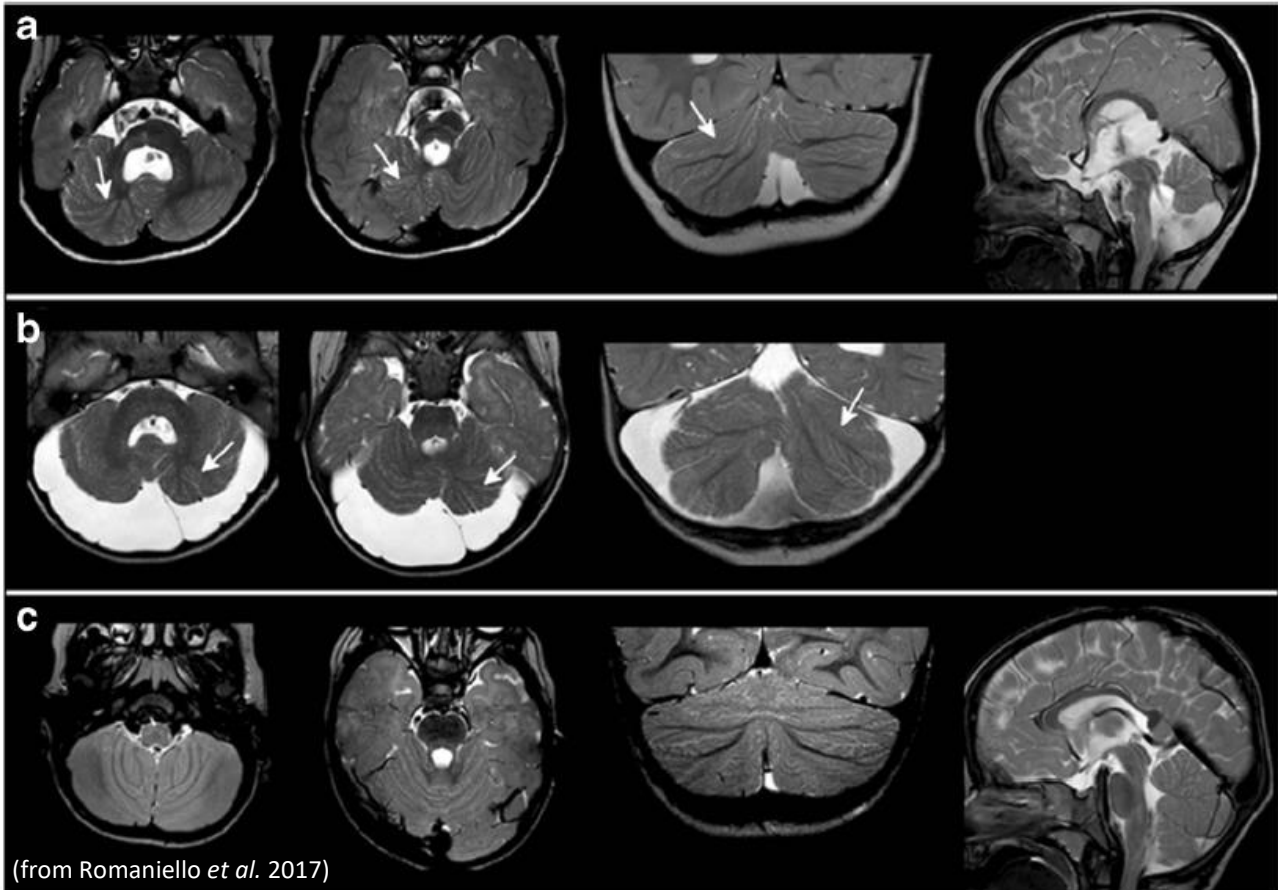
MRI findings in patients with mutations in *TUBB3* gene. Representative MRI findings from two patients. (A) Right cortical cerebellar dysplasia with vermian hypoplasia and rotation, small brainstem cleft, thick left malformation of cortical development (MCP) and short pons (B) Left cortical cerebellar dysplasia (C) Normal orientation of cerebellar folia.
